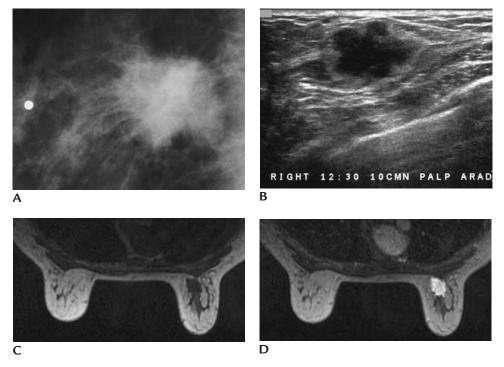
Invasive lobular carcinoma. (A) Dense mass with spiculated margins corresponding to palpable finding (metallic BB). (B) Irregular, hypoechoic mass with lobulated margins and a thick echogenic rim. Approximately 90% of spiculated masses are malignant and of these approximately 20% are invasive lobular carcinomas. (C) Magnetic resonance imaging. Precontrast T1-weighted image. (D) Post-contrast T1-weighted image at same table top position as (C). Mass with low signal intensity on pre-contrast images and rapid initial enhancement and wash out on the contrast images.
